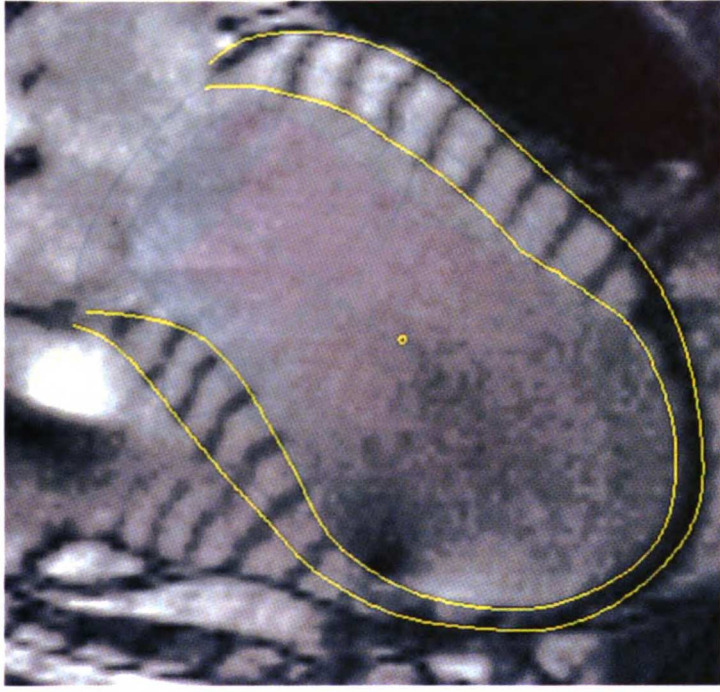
MRI Data acquisition (Images reproduced from Guccione [1])
